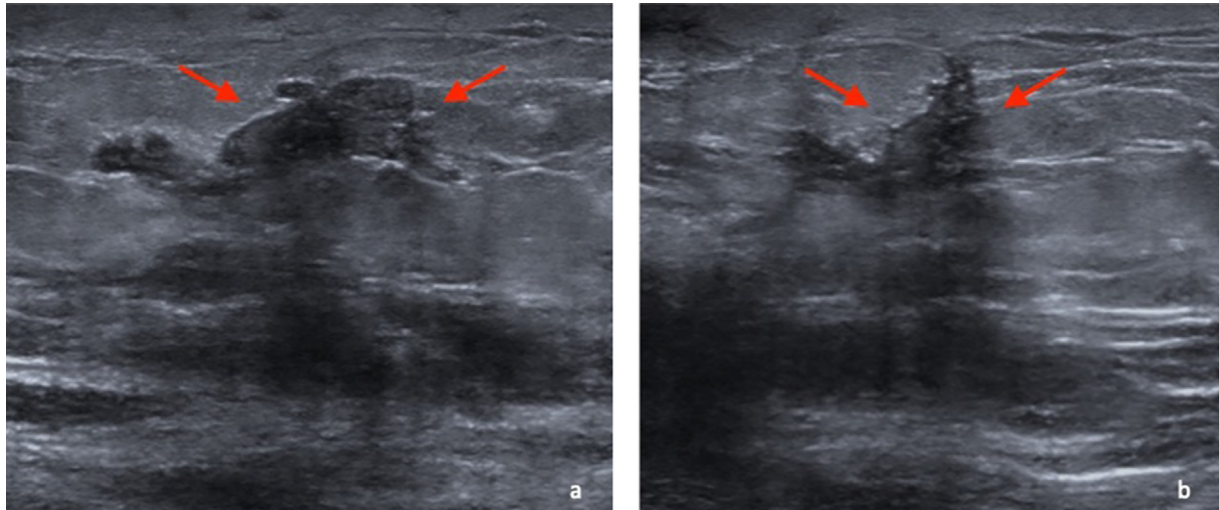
Targeted ultrasound of the left breast ([A] transverse, [B] longitudinal) demonstrated an irregular spiculated hypoechoic mass (red arrow) at 11’0 clock, 3 cm from the nipple, corresponding to the area of mammographic concern.
